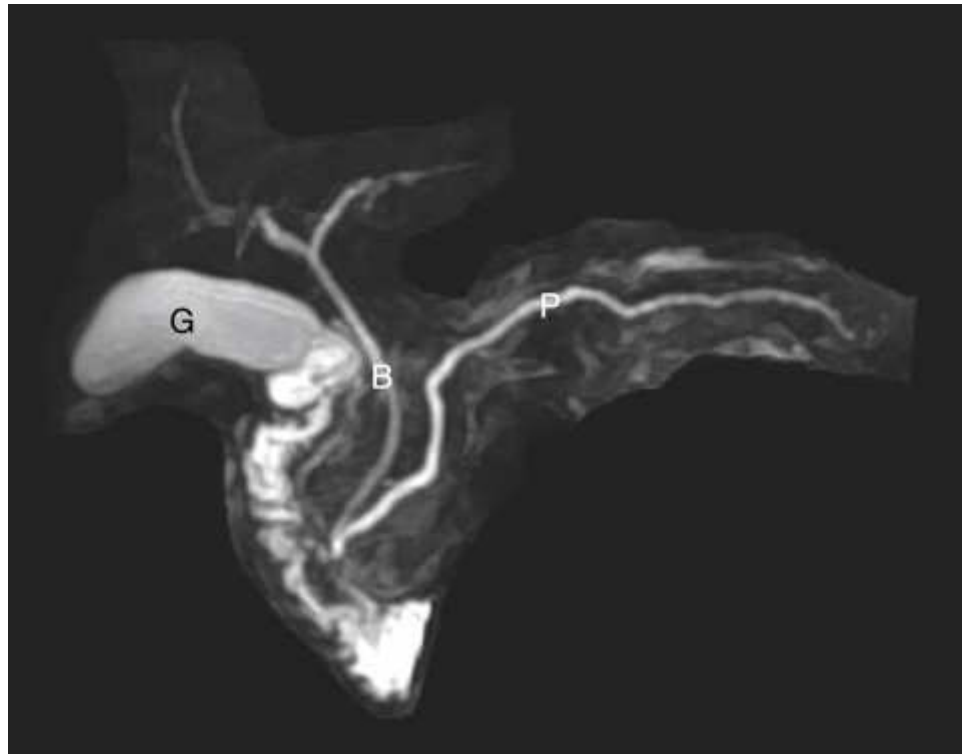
Magnetic resonance cholangiopancreatography: heavily T2-weighted images specially designed to image the gallbladder (*G*) and biliary (*B*) and pancreatic ducts (*P*).
